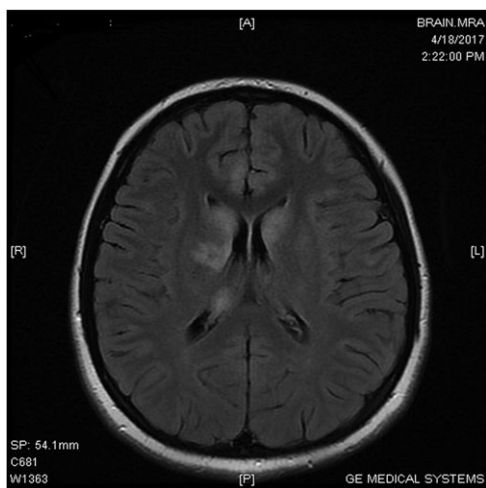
MRI brain (with gadolinium contrast) of patient on presentation showed multifocal hyper intensities in cortical and subcortical location of parietal, temporal, frontal lobes, basal ganglia, thalami, pons and left side midbrain causing localized swelling, mild compression upon frontal horns of lateral ventricles. Ring like enhancements in some lesions of basal ganglia, thalami and pons
